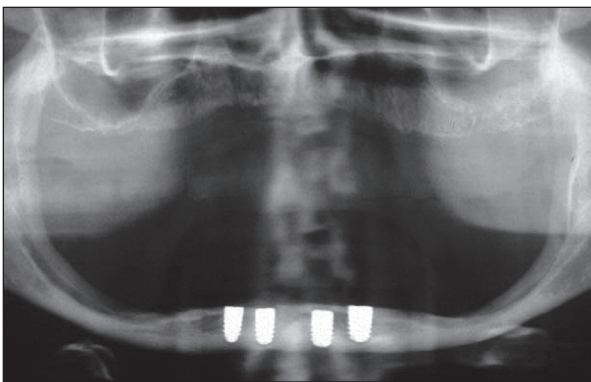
Postoperative panoramic radiograph demonstrating the implant positions.
